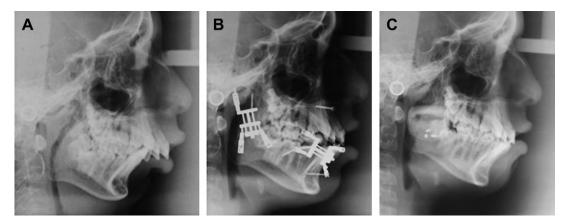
(A) Original preoperative radiograph. (B) The right mandibular ramus has been lengthened vertically and the mandibular body has been distracted anteroposteriorly simultaneously intraorally. (C) Postoperative radiograph after consolidation and arthroplasty.
